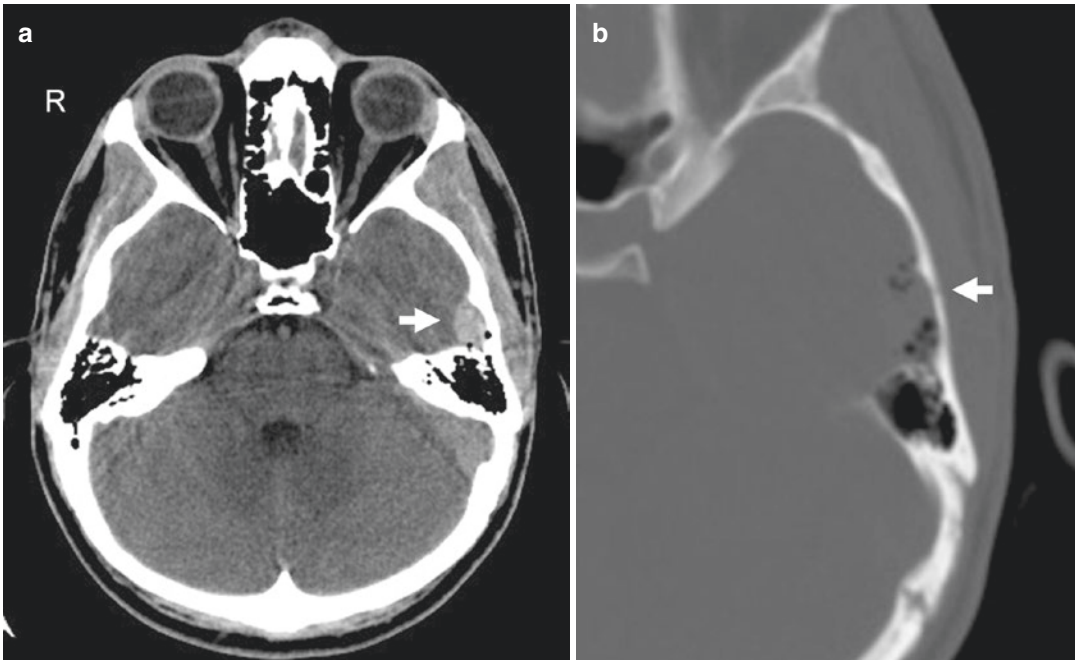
Acute EDH. (a) Non-contrast axial CT shows a characteristic hyperdense, homogeneous, biconvex left temporal extra-axial collection (*arrow*). (b) An adjacent
